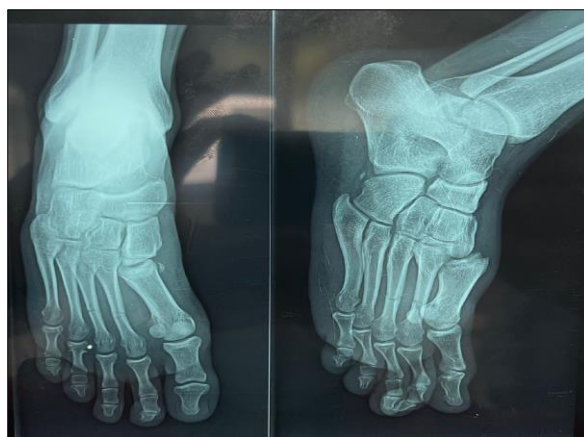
Radiography of the right foot showing a dislocated M1C1 associated with a fracture of the 2nd and 3rd metatarsal
